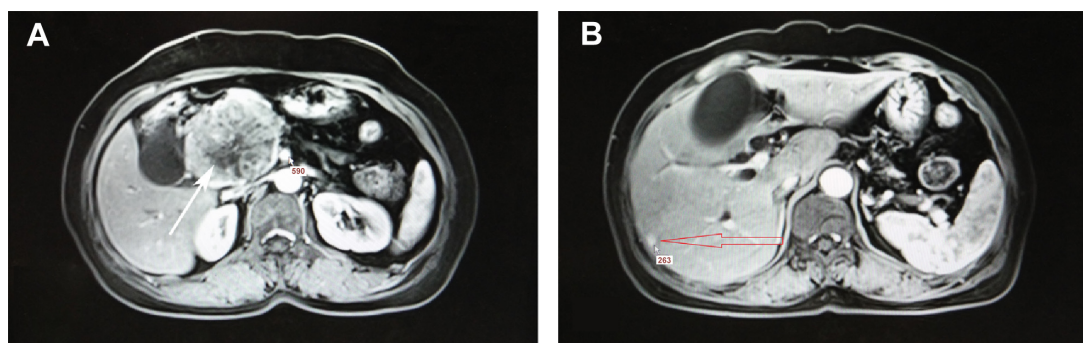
Abdominal enhanced magnetic resonance imaging with T1 findings.
